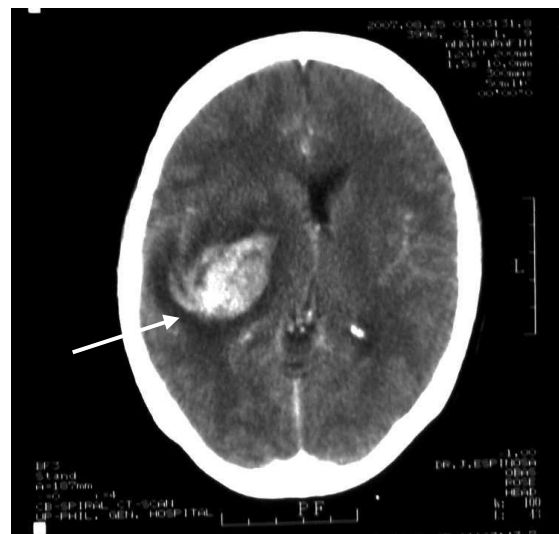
Cranial CT scan showing right capsuloganglionic bleed
